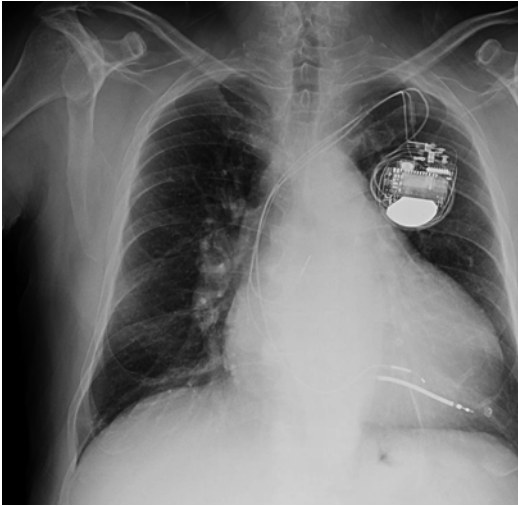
Chest X-ray. The cardiac shadow is slightly enlarged due to an increase of cardiac transverse diameter. A left-sided pleural effusion obliterates the costophrenic recess and is associated with a bilateral hilar enlargement with widespread bronchovascular marking and interstitial pulmonary congestion. The presence of right ventricular and atrial leads and coronary sinus lead
